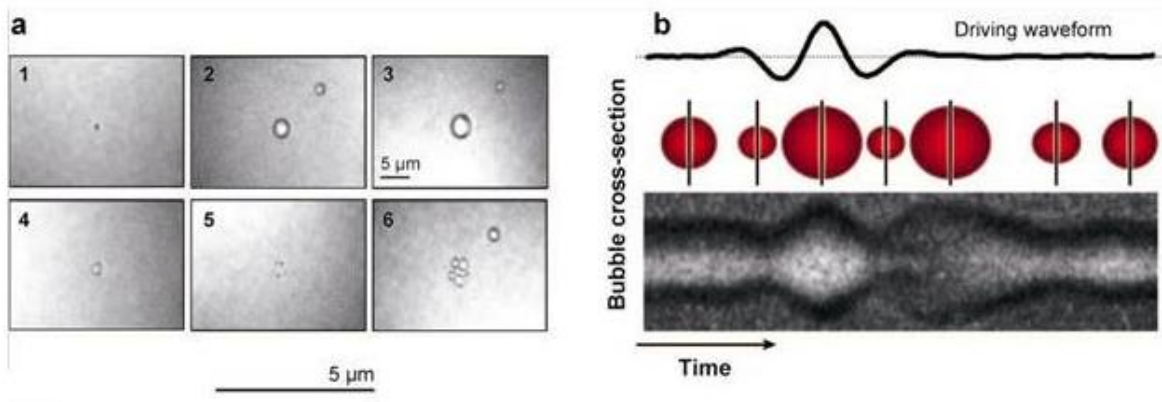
(a) Sequence of two-dimensional images of a microbubble oscillation affected by a 2.25-MHz center frequency pulse ultrasound over 10 nanoseconds. (b) Radius-time image of a microbubble oscillation and a distance-time image of a single line through the center of the microbubble oscillation for characterization of the effect of ultrasound on the microbubble. Reproduced from Ferrara et al. [21] with permission.
